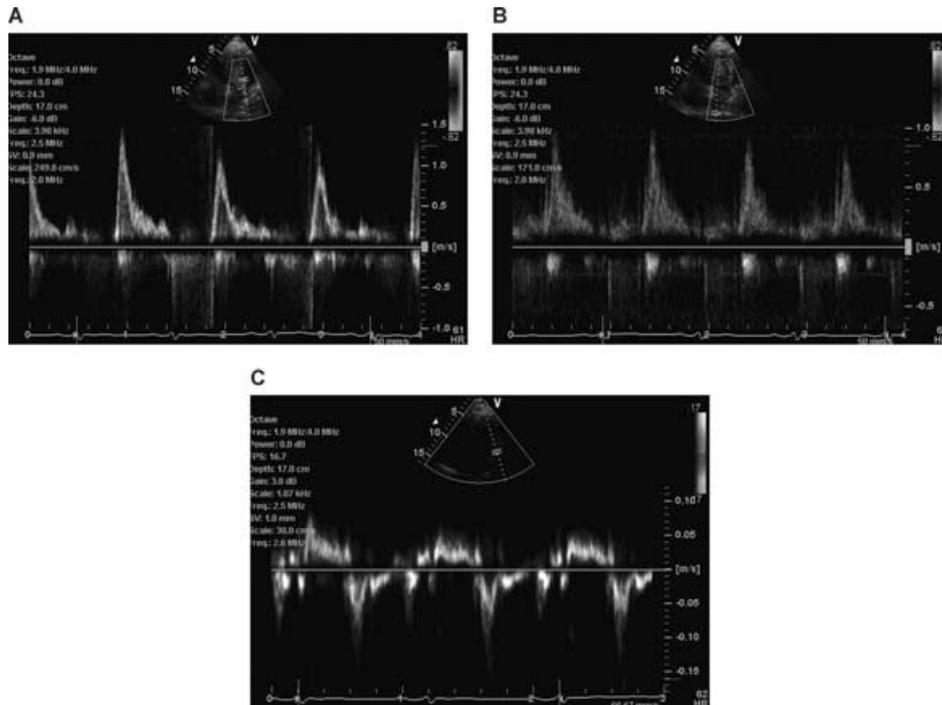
Pulsed-wave spectral Doppler from TTE performed 10 days after RFA showing transmitral inflow (A), left atrial filling (B), and tissue Doppler (C). The restrictive filling pattern persists.
